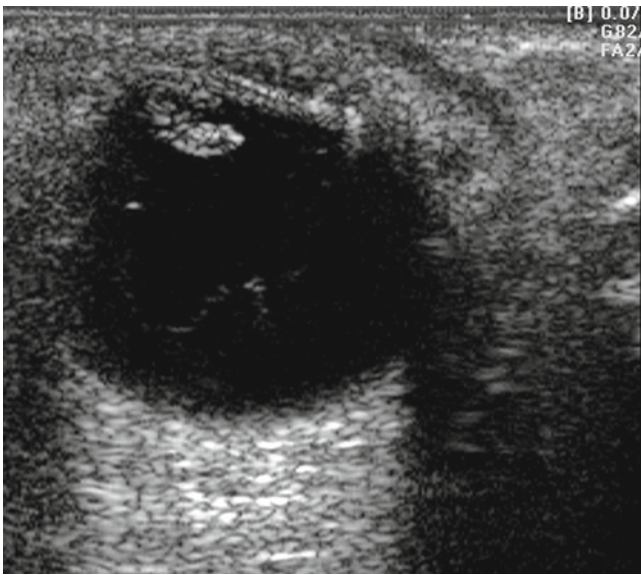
An ultrasound of a patient with chronic uveitis after cataract extraction reveals lens material trapped in the capsule stimulating the uveitis
